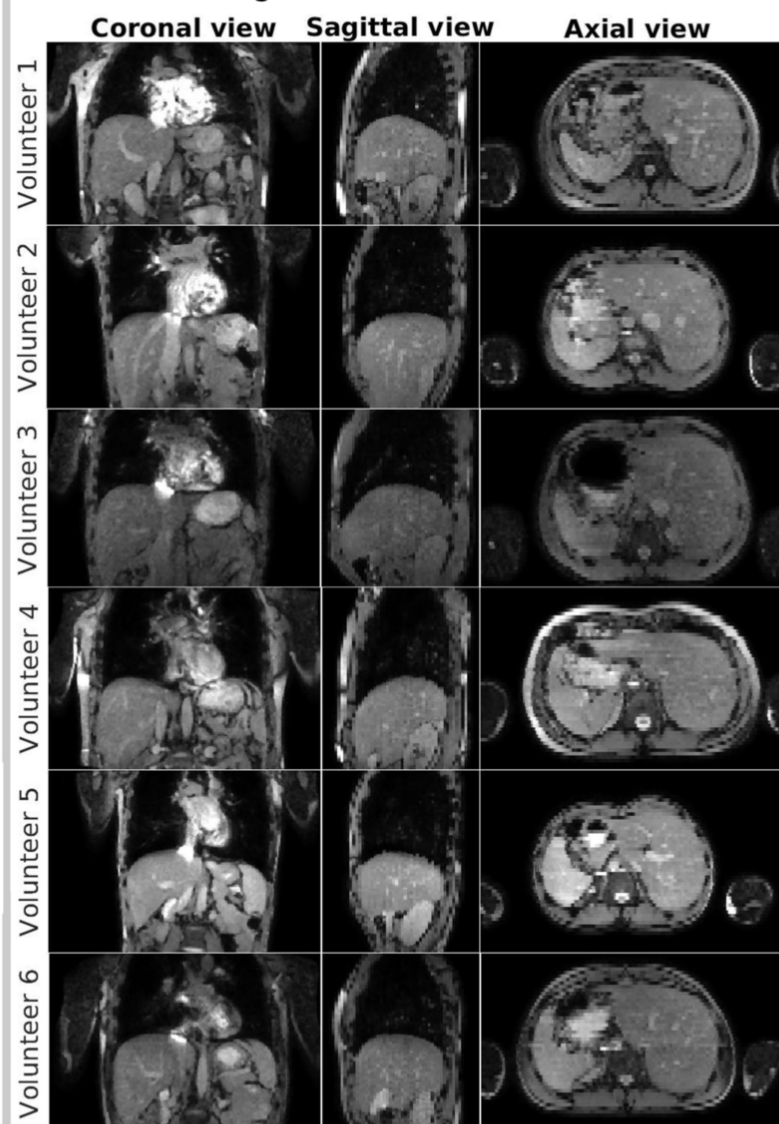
Reconstructed SMS-4D-MR images (end-exhale shown). Note that the arms are partly invisible due to REST slabs placed outside the body contour.
